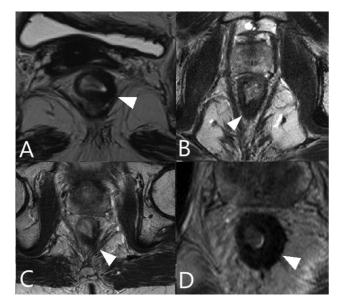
Morphological appearance of complete response (cCR) on magnetic resonance imaging (MRI). (A–D) Response assessment MRI following long-course chemoradiotherapy (LCRT) in four different patients with a pathological complete response showing variable thickness T2 hypointense scar (arrowhead). The posttreatment fibrosis extends to the left puborectalis in A and C (circumferential resection margin [CRM] involved).
